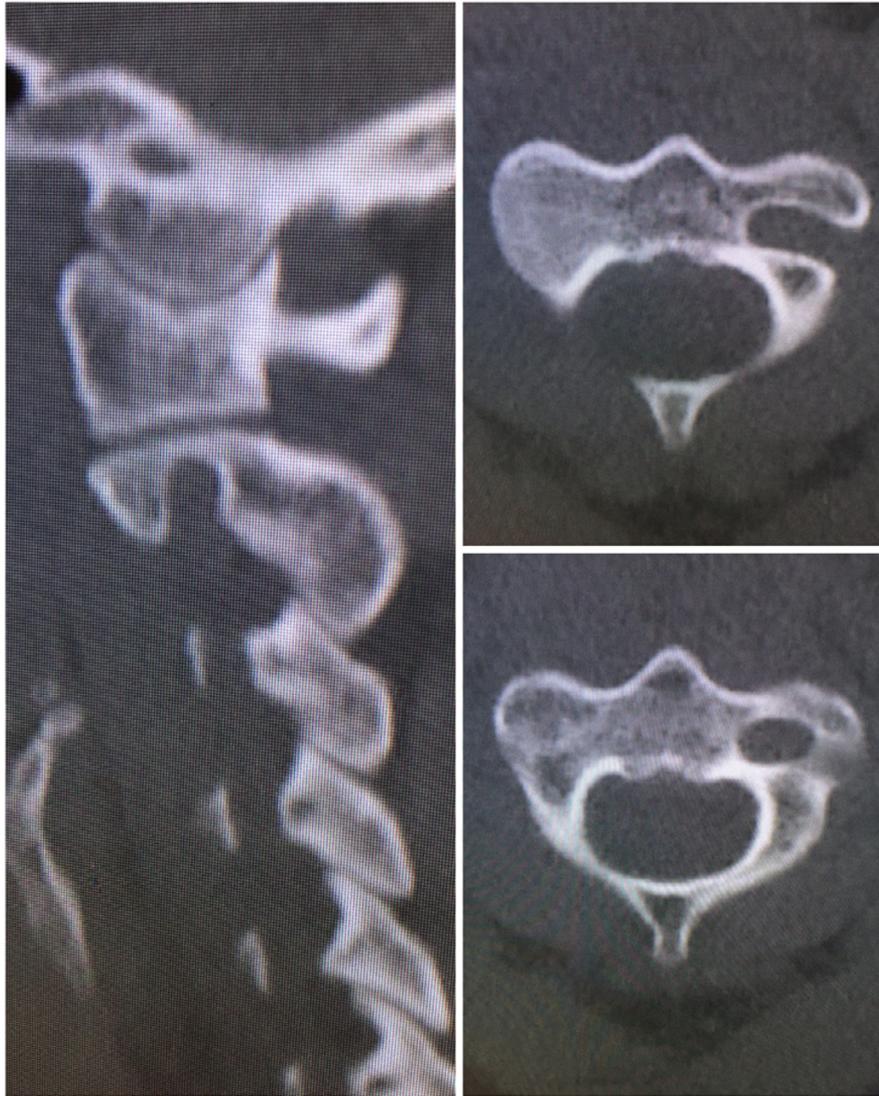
Aberrant left vertebral artery seen on preoperative computed tomography scan. Such anatomy may preclude the placement of safe instrumentation.
